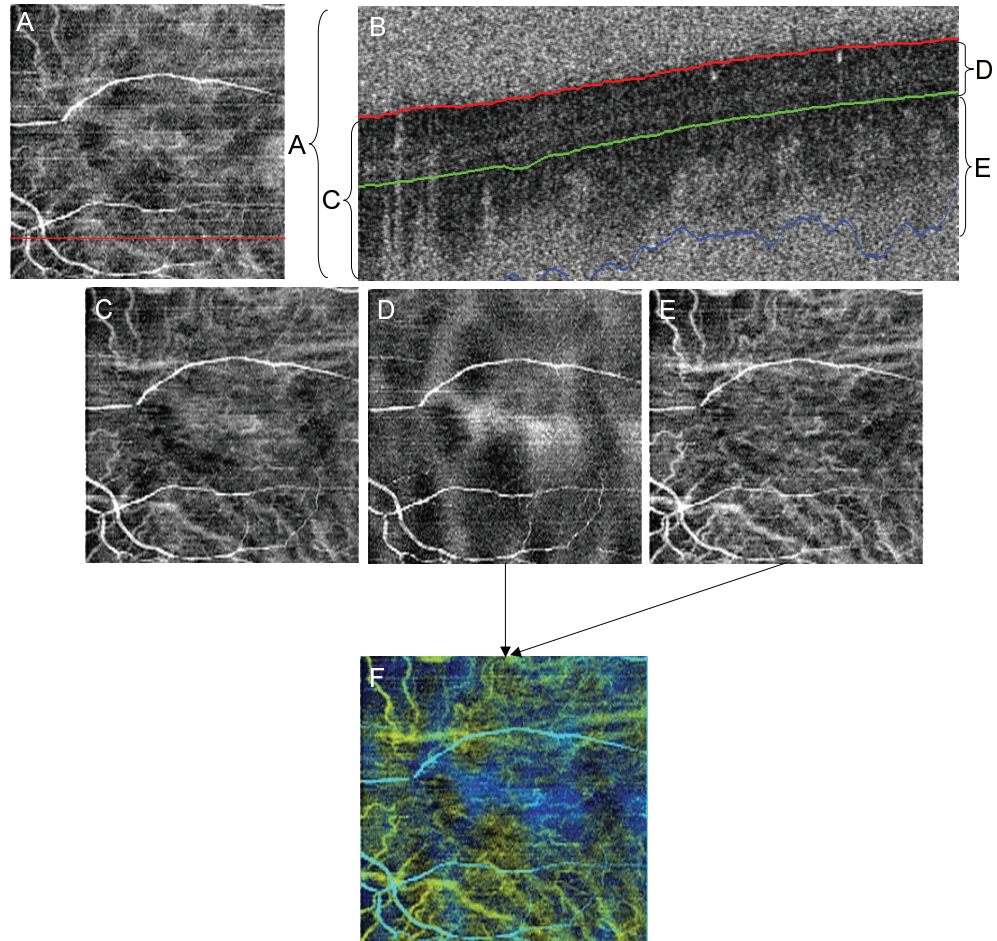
Optical coherence angiography of the macula lutea of the human eye. Each image is produced by the integration of (A) the entire depth, (C) tissue region, (D) retinal part, and (E) choroidal part of the power of Doppler shift images. (F) is a combination of (D) and (E). In the cross-sectional flow image (B), each integration range is indicated.
